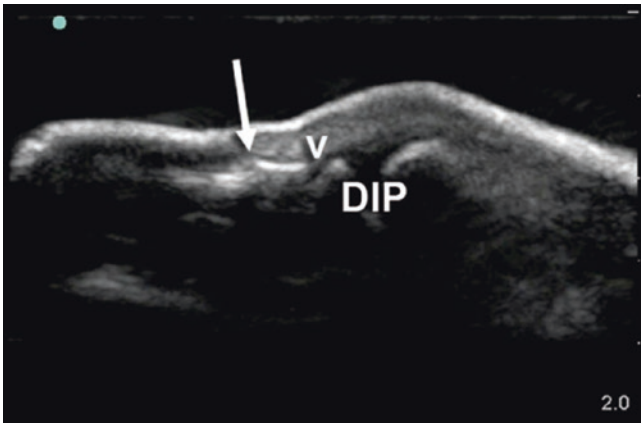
This long-axis view demonstrates a fracture of the distal phalanx which was not evident on X-ray. Moving from image right (proximal) to image left (distal), bony cortex appears as a bright white horizontal line interrupted by the distal Interphalangeal (DIP) joint, growth plate (*down arrowhead*), and then the fracture (*arrow*)
